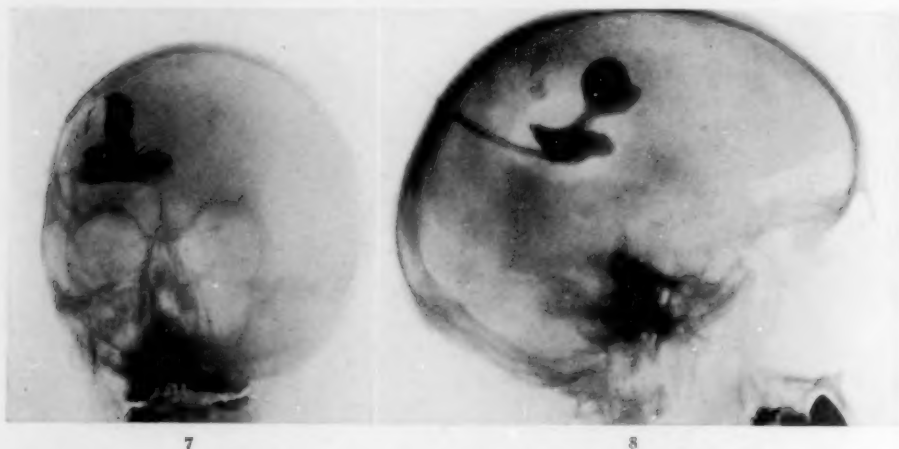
Antero-posterior view eleven days after radiograph, Fig. 5. Comparison with this shows the diminution in size and change in shape of the cavity.
